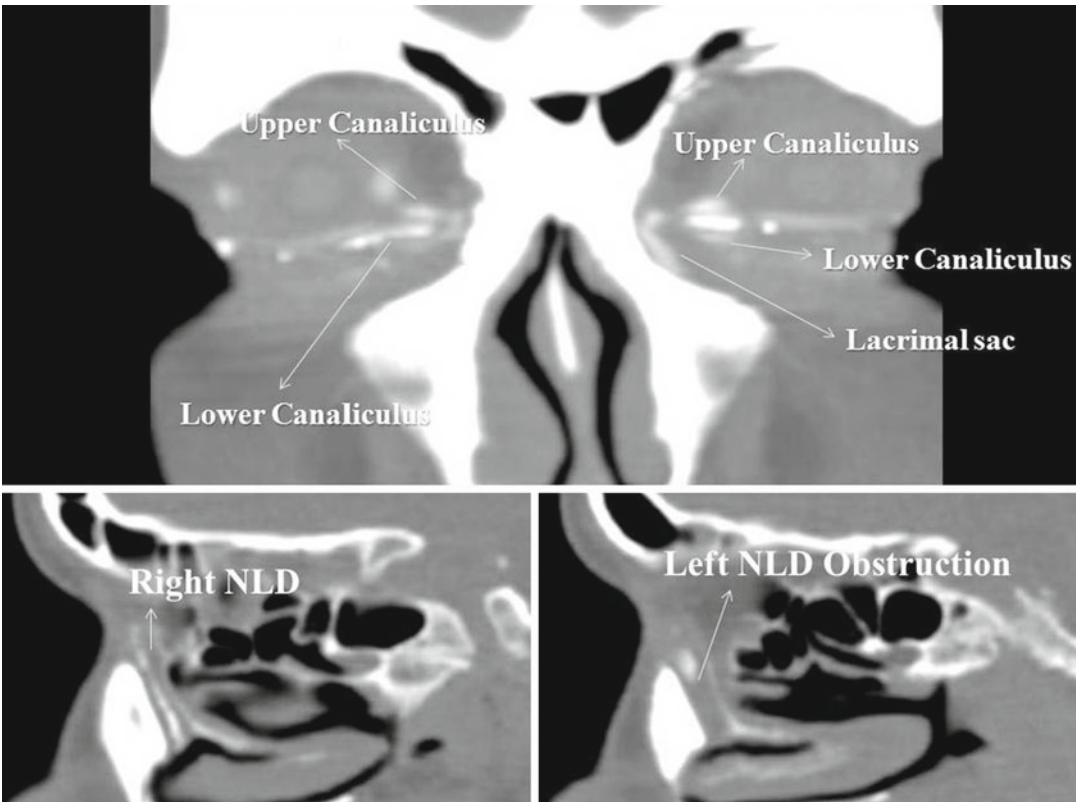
Computed tomography–dacryocystogram. *NLD* nasolacrimal duct
